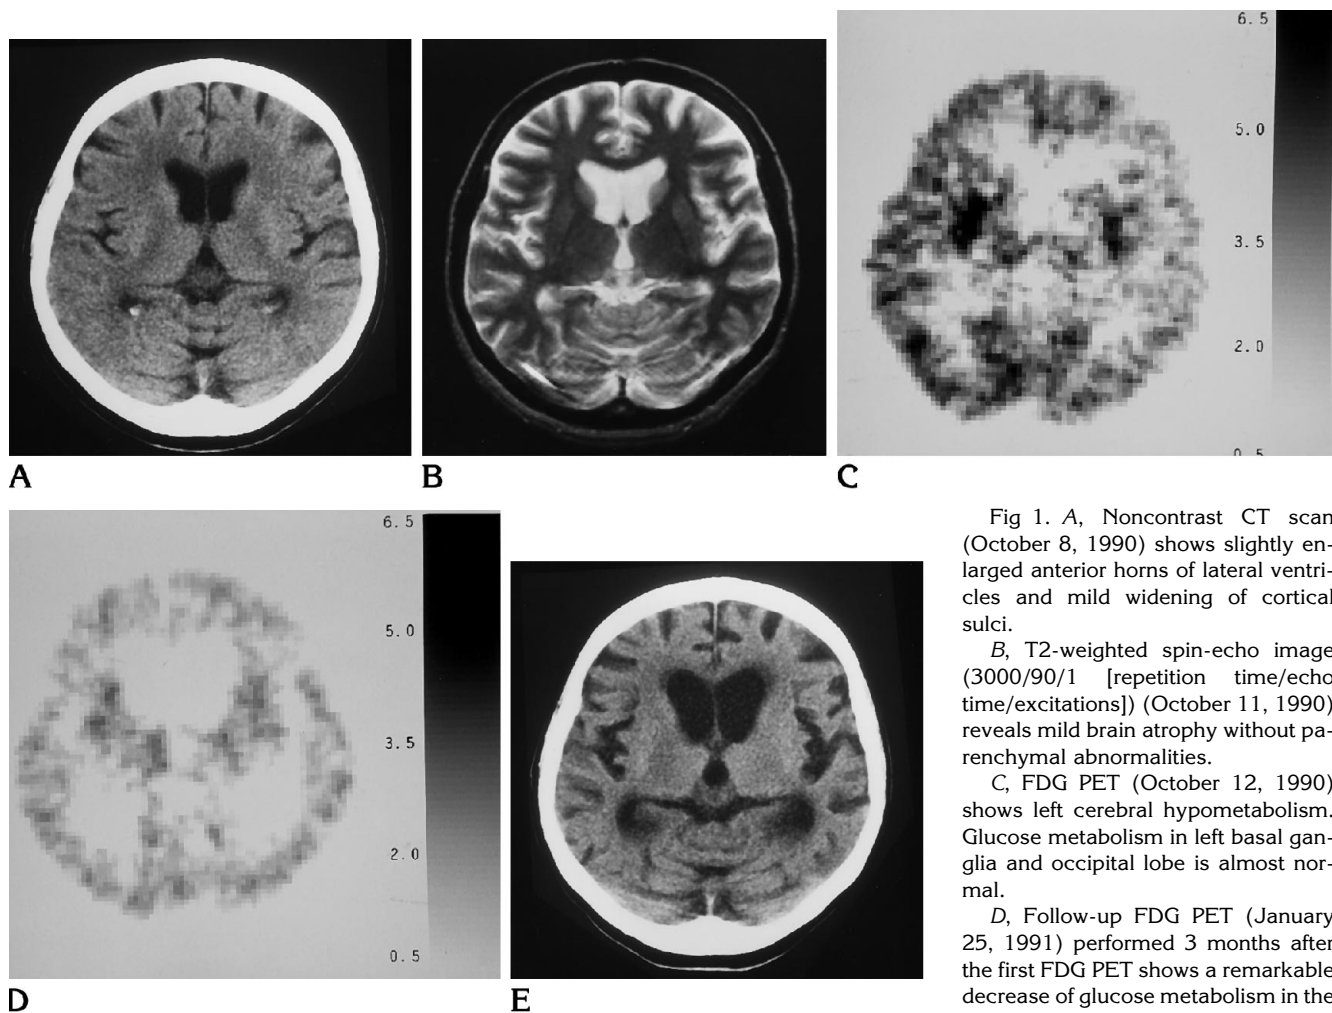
A, Noncontrast CT scan (October 8, 1990) shows slightly enlarged anterior horns of lateral ventricles and mild widening of cortical sulci.
